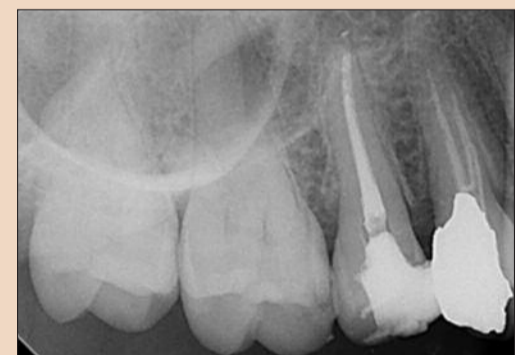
Radiograph of contralateral side
